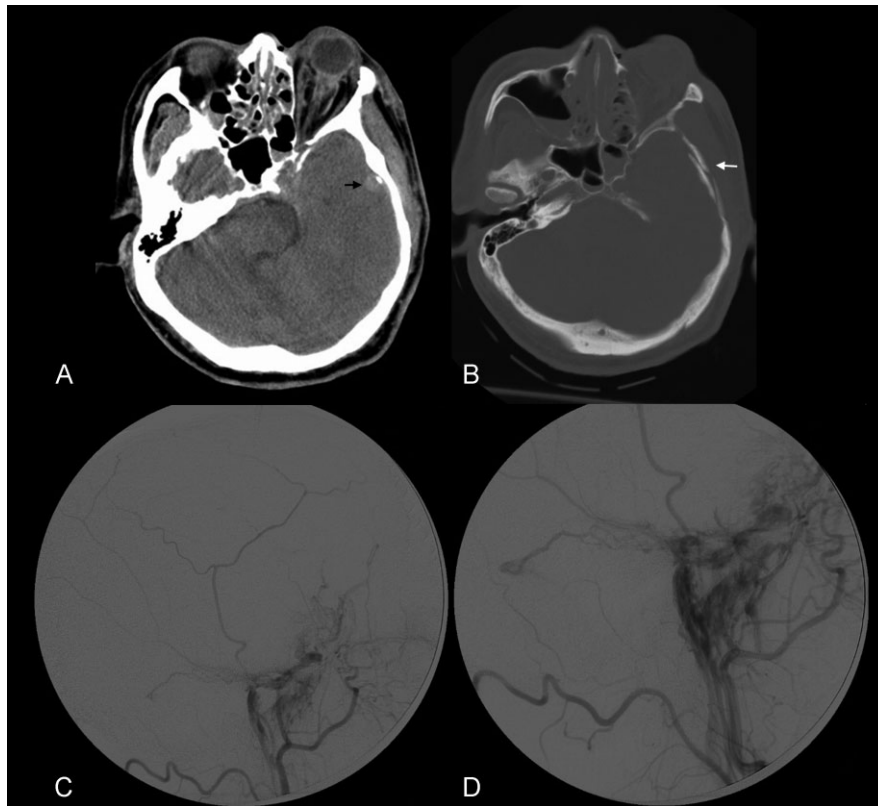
Dural arteriovenous fistula. (A) The axial computed tomography image displayed in the soft tissue window shows a small, round, dense, left temporal extra-axial focus (arrow). Left orbital proptosis and retrobulbar soft tissue stranding can also be seen. (B) The corresponding bone window image shows an associated temporal bone fracture (arrow). (C,D) Images from an external carotid artery cerebral angiogram in the lateral projection show blush of contrast due to filling of the middle meningeal vein via the middle meningeal artery.
